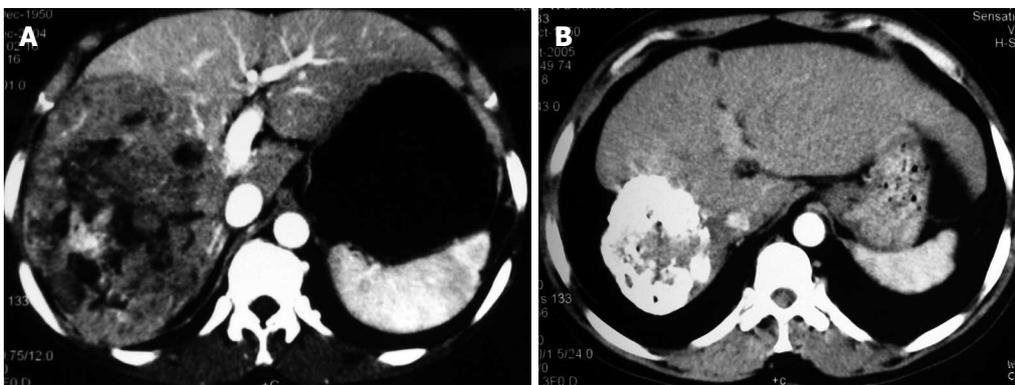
Contrast computed tomography scan showing a 15 cm × 11.5 cm hepatocellular carcinoma in the right liver lobe manifested as a heterogenous lower density, partial enhancement and well-differentiated contour (A) and computed tomography follow-up displaying the significant regression of a 8.5 cm x 6 cm lesion with compact lipiodol deposit in a 72-year-old man after 3 p53 gene injections and 4 courses of transcatheter hepatic arterial chemoembolization.
